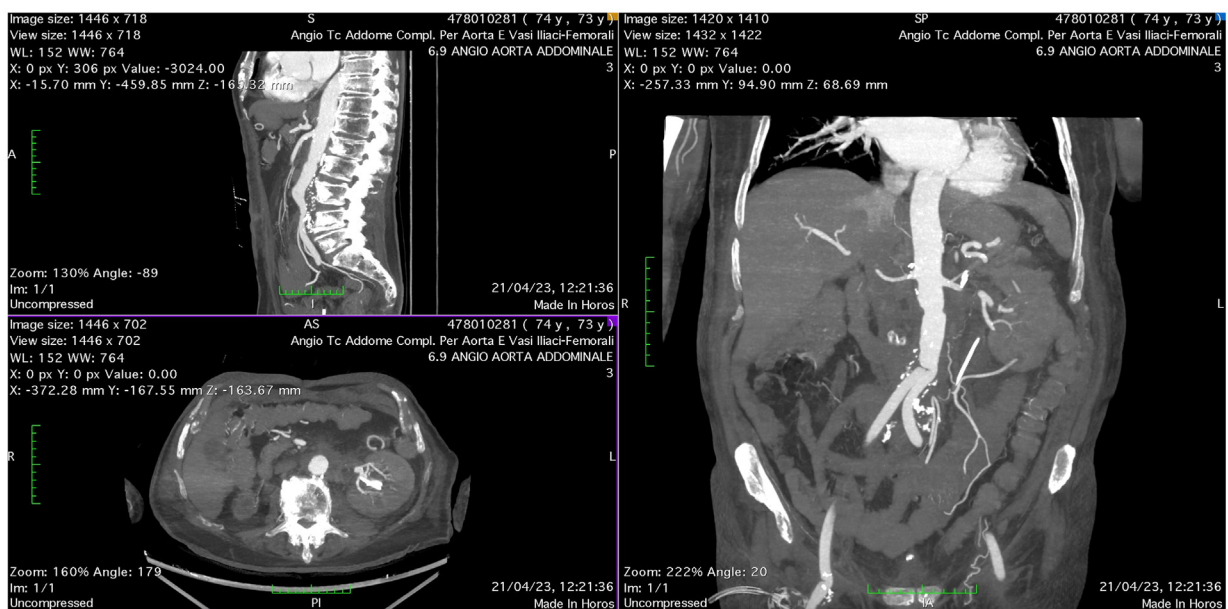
Follow-up computed tomography angiography (CTA) 2 months after explantation and in situ reconstruction.
